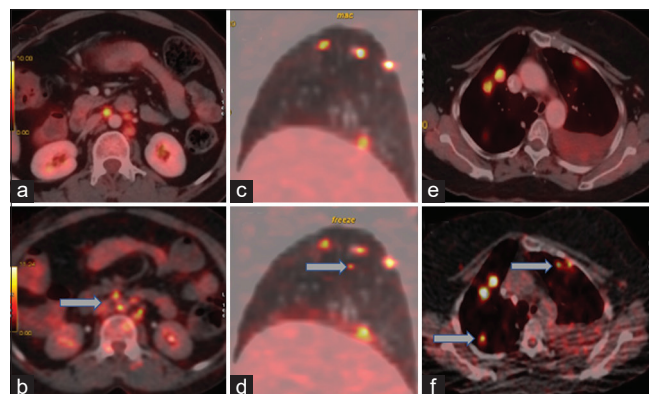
(a, c and e) Nongated axial and sagittal images and (b, d and f) its corresponding gated images. Few new FDG-avid abdominal lymph nodes and lung nodules were detected/better appreciated after respiratory gating (arrows in b, d and f)
